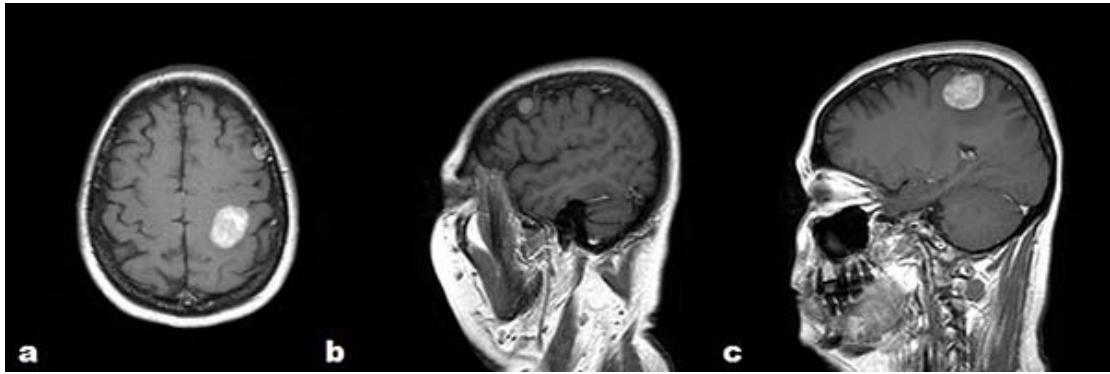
Axial (a), sagittal(b,c) gadolinium-enhanced T1-weighted MRI scans showing two extra axial hyperintense masses.
